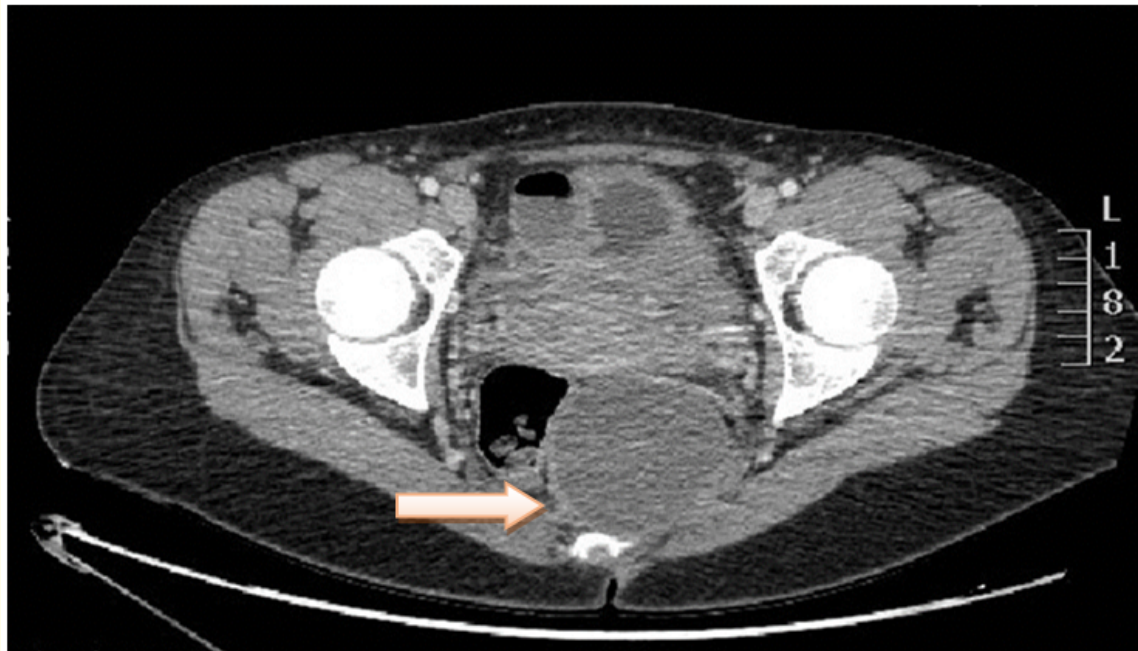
CT Scan showing retrorectal cyst.
